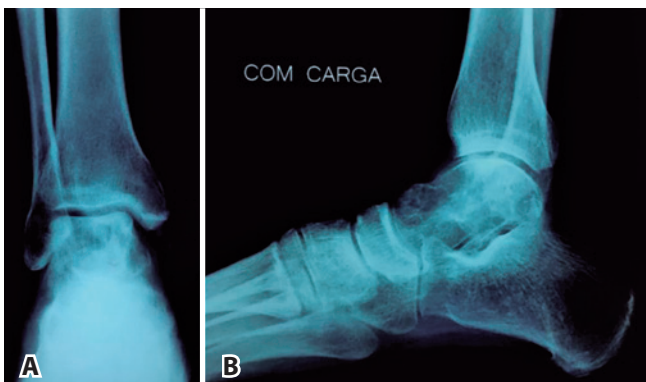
X-rays from the initial investigation of the left ankle. A) X-ray, anteroposterior view. B) X-ray, profile view.
